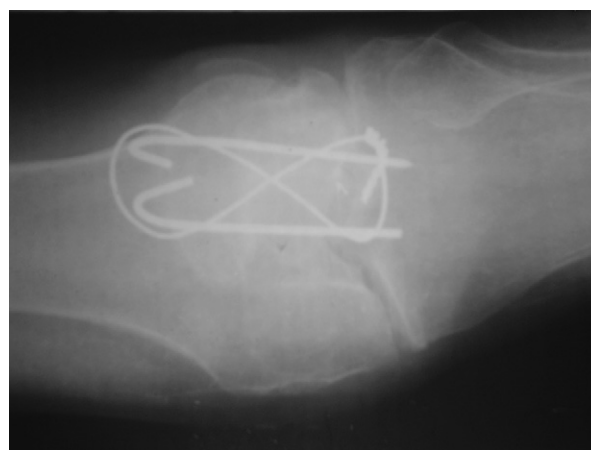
Postoperative radiograph showing features of union (anteroposterior view).
